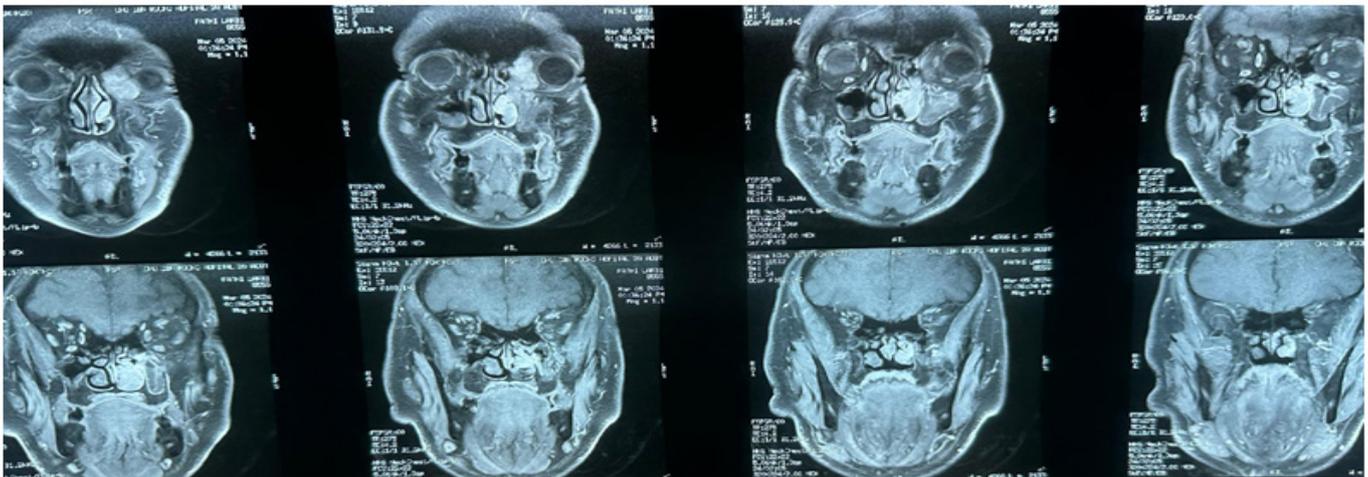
Lesion at the left medial canthus that was hyperintense on T1-weighted images.
